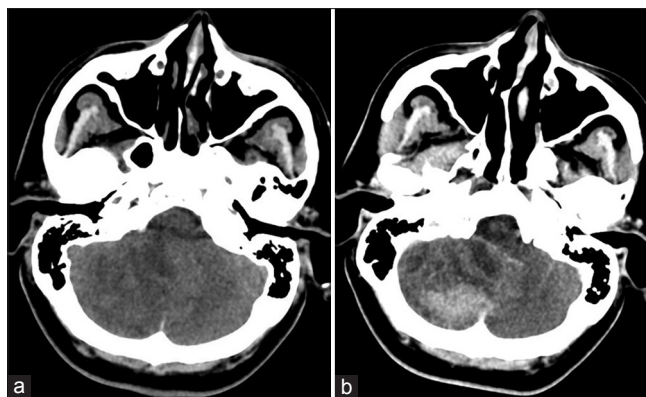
Noncontrast head CT (a) demonstrating an ill-defined hypodense lesion in the right cerebellar hemisphere causing compression of the 4th ventricle. Contrast-enhanced head CT (b) demonstrating an ill-defined, mildly enhancing right cerebellar lesion. The indistinct appearance of cystic structures can be appreciated surrounding the area of enhancement
